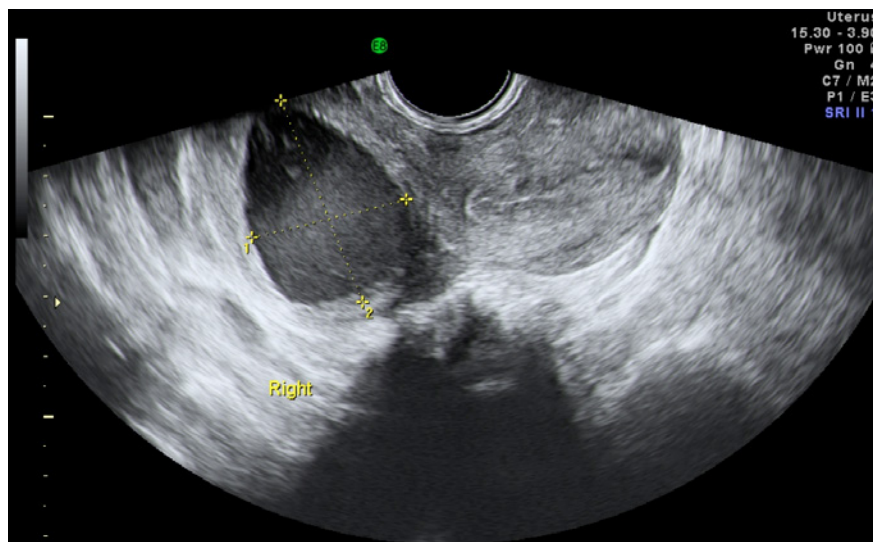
Ultrasound showing a non-communicating rudimentary horn
